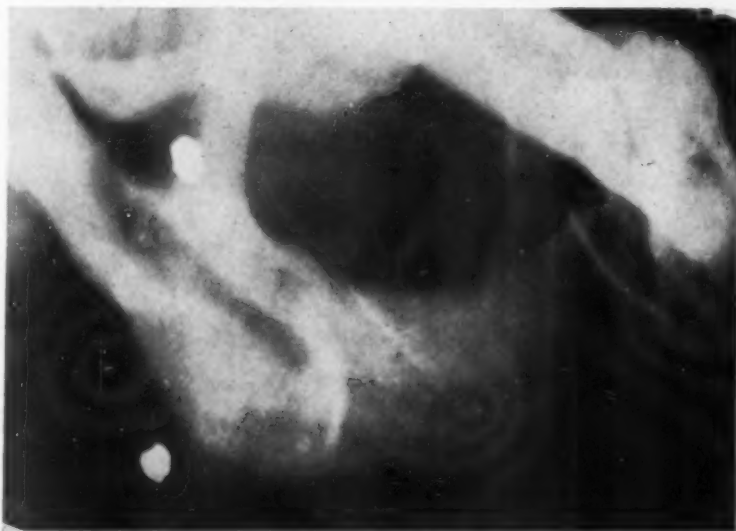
Lateral x-ray showing mandible after the sequestrum was removed. The two white points are the leads holding the subcuticular suture.
